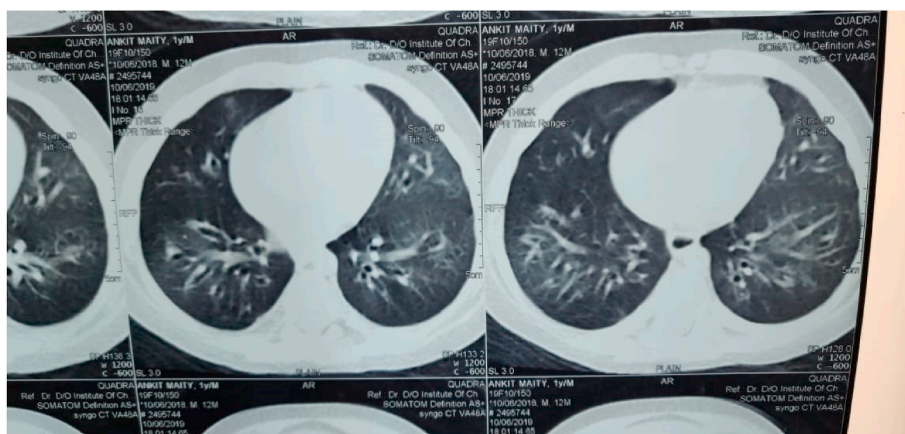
High Resolution CT images showing bilateral bronchiectasis with ground glass opacities suggestive of bronchiolitis obliterans, a sequelae developed in this case.
